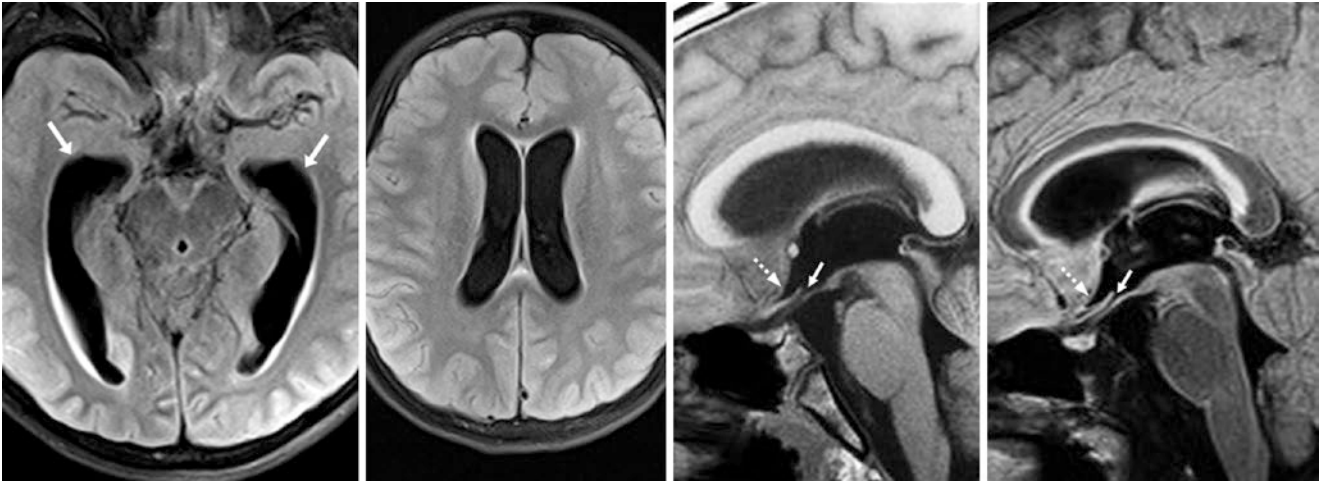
Comparison case of hydrocephalus from bacterial meningitis. An 11 year old had mild to moderately enlarged temporal horns (arrows) and bodies of the lateral ventricles on axial FLAIR images (left two images). On sagittal T1WI (right middle) and FLAIR (right), the optic recess of the anterior third ventricle (dotted arrows) is mildly
